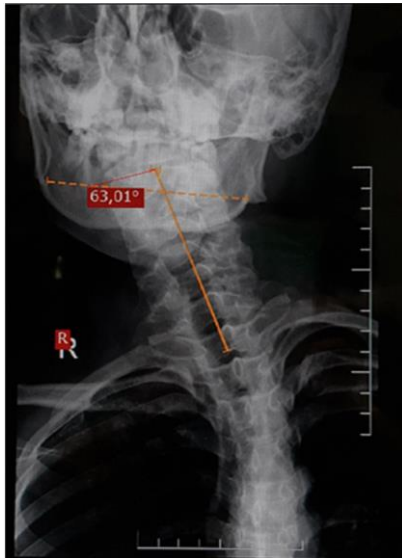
Radiographic evaluation during the preoperative
